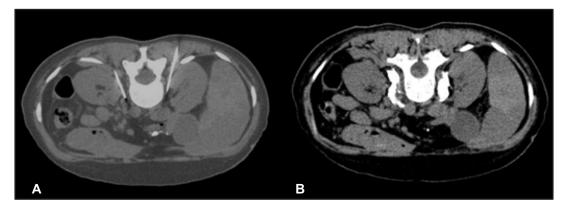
A) Axial CT scan image of a patient with neuroendocrine tumor of pancreas with liver metastases in pron position demonstrating needle position for providing celiac block by neurolysis B) Small amount of anhydrous alcohol is injected after which patient reported good pain relief
